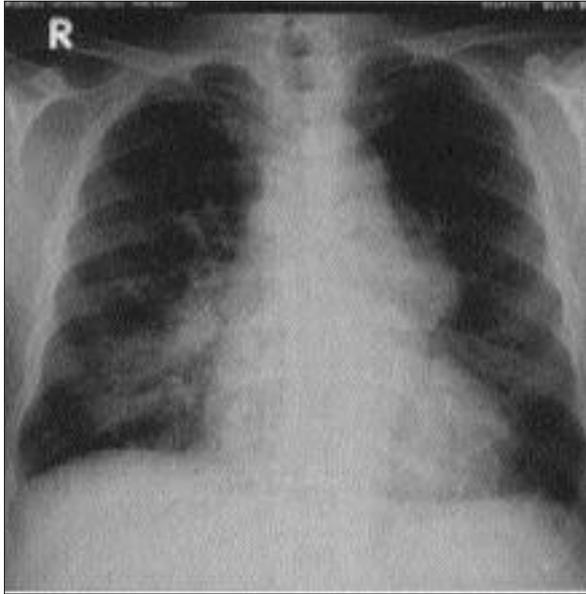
Posteroanterior chest roentgenogram reveals cardiomegaly, vascular redistribution, markedly dilated main pulmonary artery, inhomogeneous density in both lungs, especially in the right lung.
